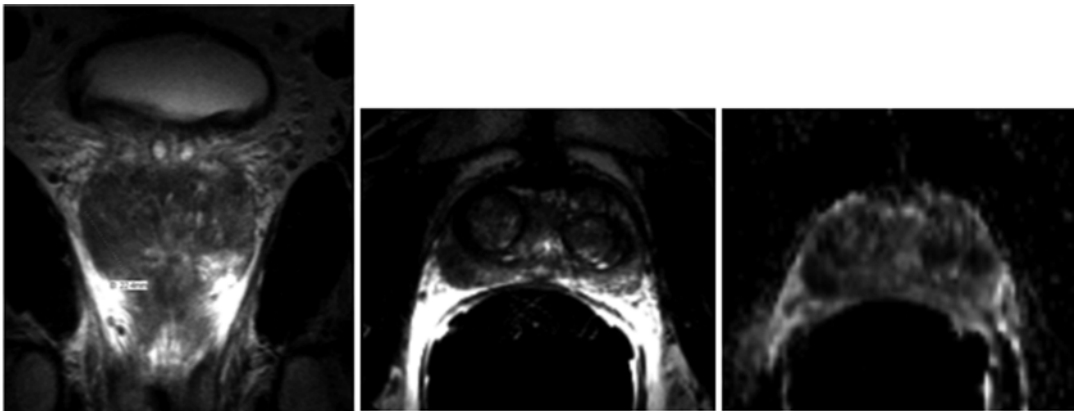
Multiparametric MRI (MP-MRI) with 1.5T magnet and endorectal coil shows large volume disease from the right apex to base with possible EPE at the right apex (*left side coronal*). The cross sectional T2 (*center*) and diffusion weighted image map (*right*) show
